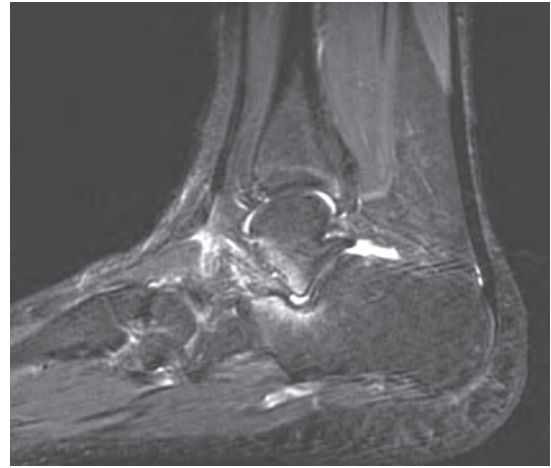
Magnetic resonance image showing a stress reaction of the calcaneus and the talus.
